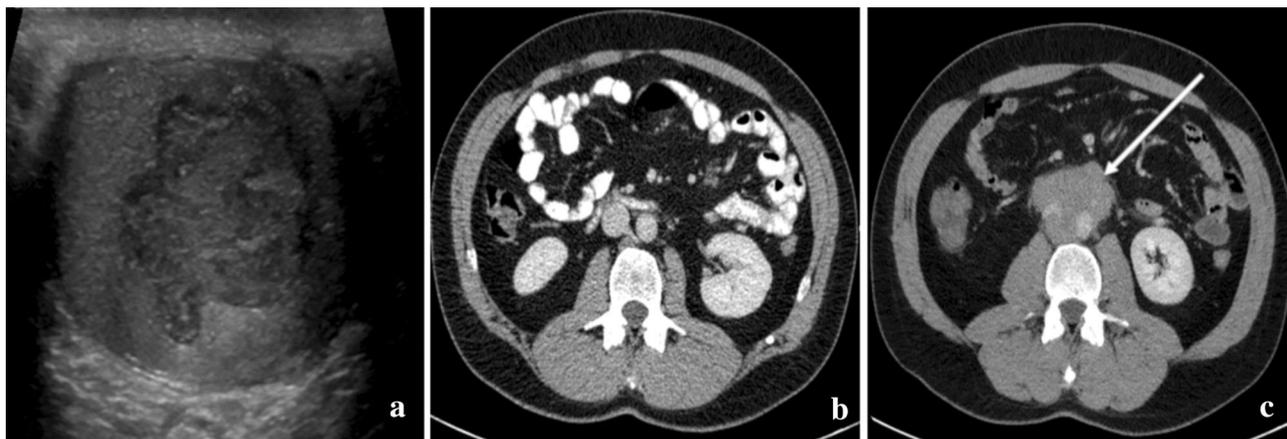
37-year-old male with left testicular seminoma. At the time of presentation, ultrasound (a) and CT of the abdomen (b) revealed a heterogenous lesion in the left testis without metastatic retroperitoneal adenopathy, respectively. Serum tumor markers, including AFP, HCG, and LDH, were within normal limits. Routine evaluation
